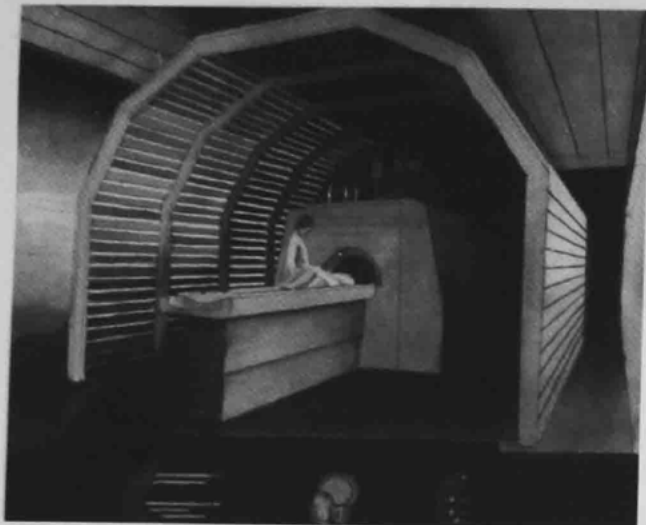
"Magnetic Resonance Imager"
